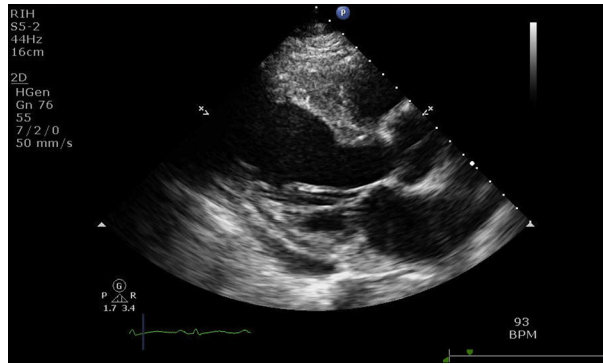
Parasternal long-axis view revealing a mildly dilated left ventricle with a small pericardial effusion.
